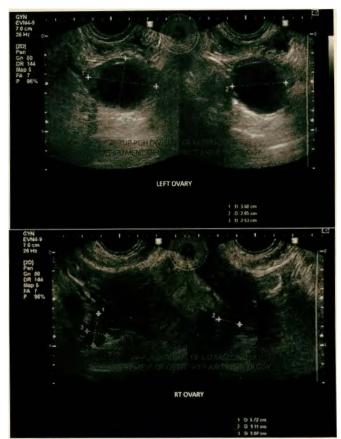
Transvaginal ultrasound: Within the left ovary is a unilocular cyst measuring 3.7cm x 2.9cm x 2.6cm (volume: 14.6cc) with low-level echo fluid within. There are no solid areas or papillary excrescences seen. There is normal ovarian stroma at the periphery. The right ovary is normal and measures 1.7cm x 1.1cm x 1.1cm (volume: 1.1 cc).
